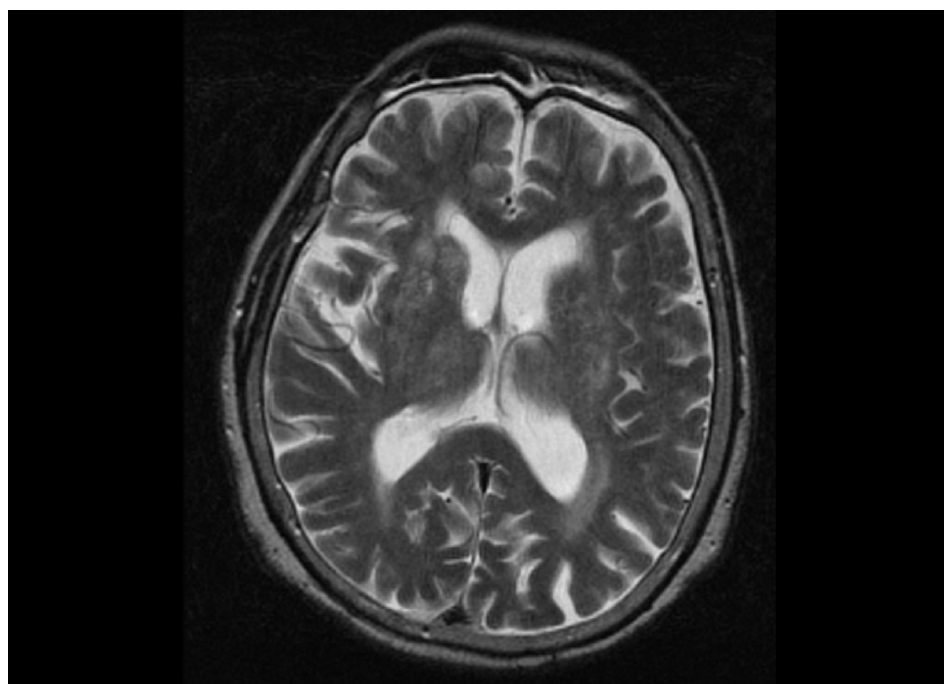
The T2 weighted image with contrast showed bilateral periventricular white matter changes on MRI.
